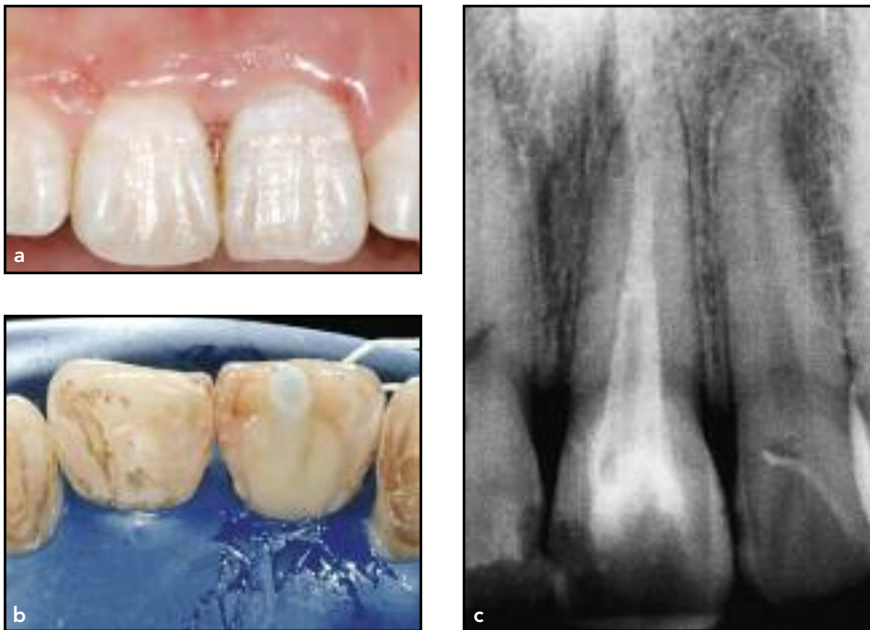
One week postoperative. (a) The sutures were removed and (b) a fiber-reinforced post was inserted to reinforce the reattached fragments. (c) The treatment method was checked radiographically.
